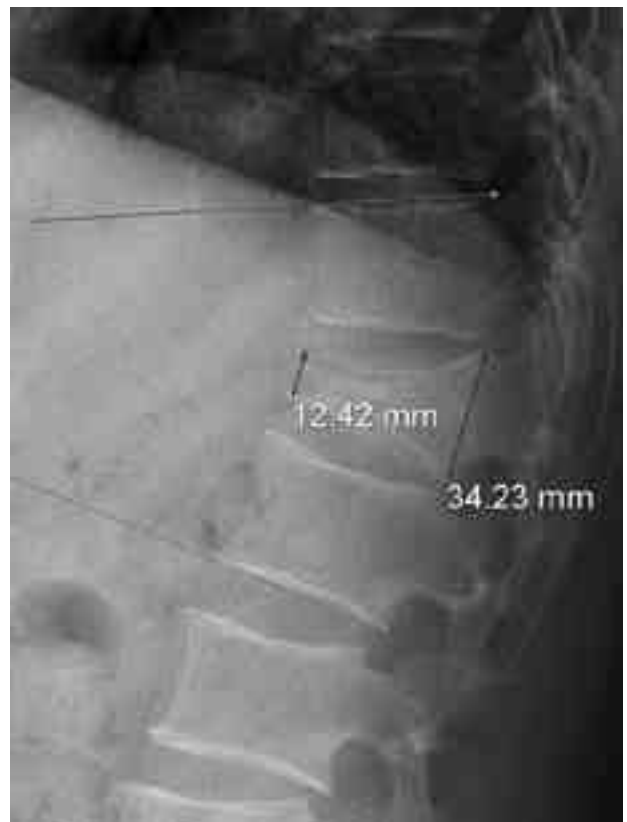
Final simple x-ray lateral view. Kyphotic angle increases to 25.4 °, and wedge compression ratio decreases to 0.37.
